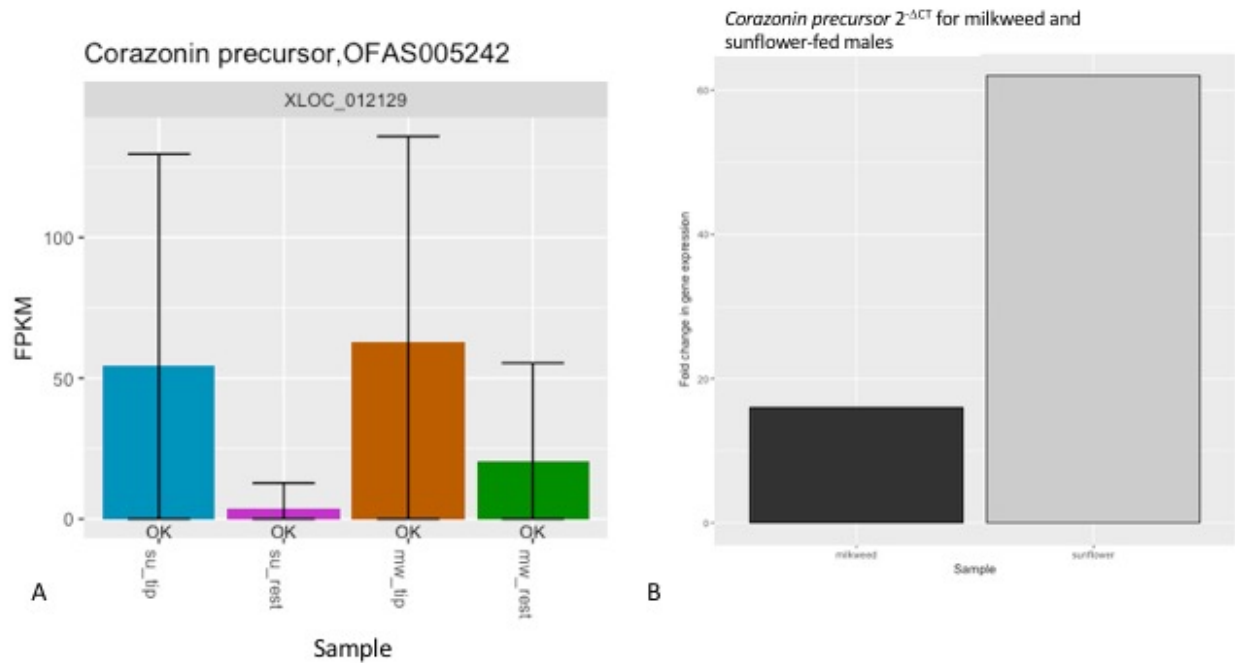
corazonin precursor* is upregulated in distal tips of testis. (A) Fragment per kilobase million (FPKM) counts for each sample and the (B) $2^{-\Delta CT}$ measurements for *corazonin precursor*. The FPKM (A) shows the relative amount of expression per sample; error bars represent the confidence interval for each sample. There is a trend for there to be more transcripts in the distal tip of both diets than in the sunflower and milkweed proximal rest. The $2^{-\Delta CT}$ values (B), show higher gene expression in sunflower-fed males than milkweed-fed males.
